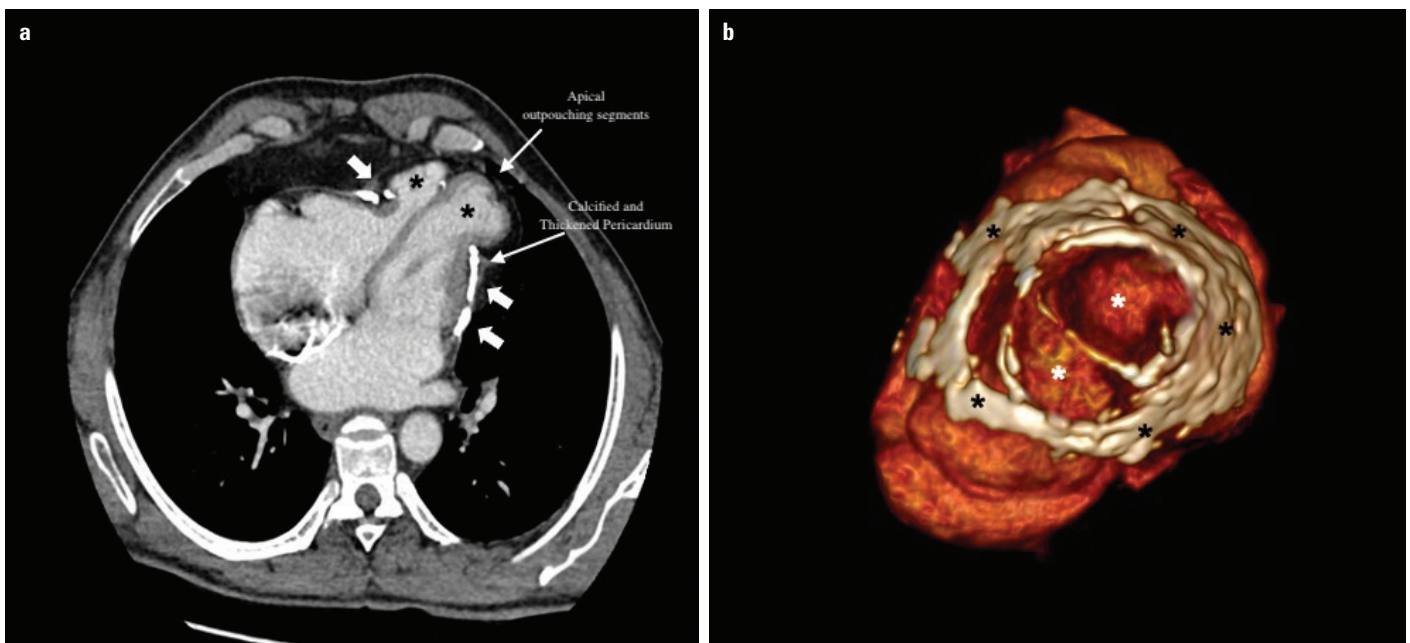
(a) Transverse contrast enhanced CT image depicting the calcified pericardial thickening of the basal and midventricular segments (thick white arrows), whereas the apical pericardium is relatively spared. Biventricular apical outpouching is noted (asterisk). (b) 3-dimensional volume rendering image of the heart clearly showing the calcified pericardial plaques (black asterisk) encircling both ventricles. Both apices are ballooning (white asterisk) through the neck of the pericardial calcified plaque
